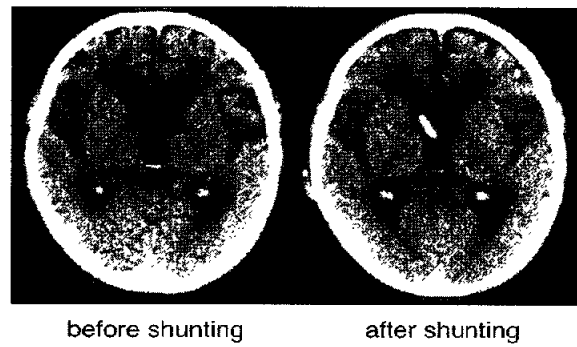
CT scans before (*left*) and 1 month after (*right*) CSF shunting revealed normalization of ventricular size without hygroma. A ventricular catheter (Hakim™ programmable V-P shunt system (Codman, MA, USA)) was installed into the right ventricle through its anterior horn. The final pressure of the shunting system was 90mmCSF
